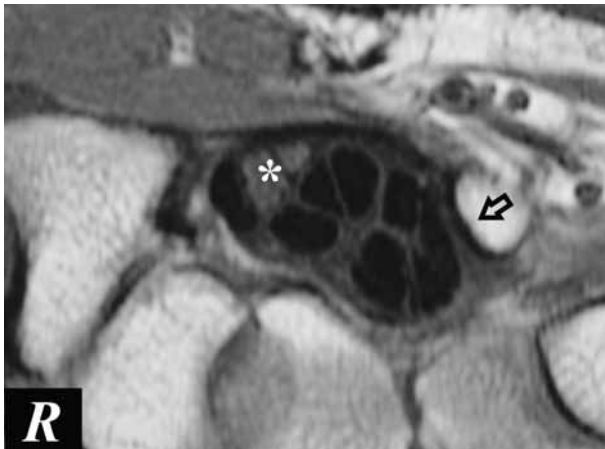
Transverse MRI-scan cut at the level of the distal margin of the carpal tunnel, on the right. Note compression exercised by the distal part of the coalition bone block (arrow) on the most ulnar flexor digitorum profundus tendons. Asterisk indicates position of median nerve.
